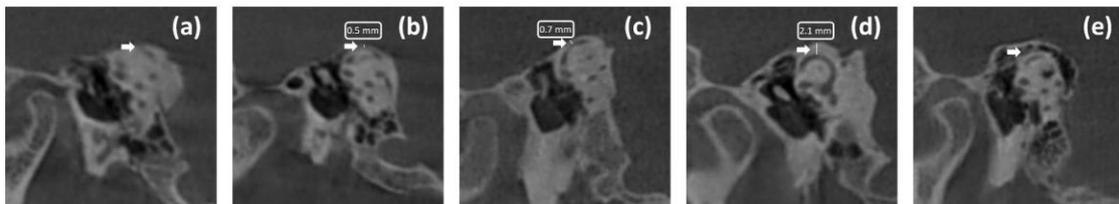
Cone-beam computed tomography images view of Superior Semicircular Canal's Types. (a) Dehiscence; (b) Papyraceous; (c) Normal; (d) Thick; (e) Pneumatized.
